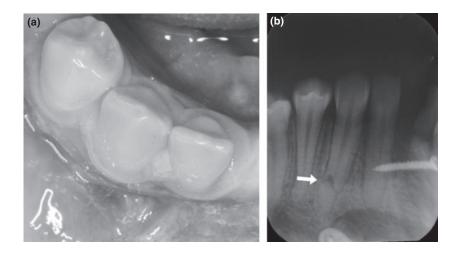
(a) Intraoral picture showing no evidence of fistulae or tissue change. (b) Periapical radiograph of the patient showing root fracture, with а radiolucent area (arrow), as possible root resorption. Note the well-defined smooth radiopaque outline immediately below the apex of 43 located at the mid line of the inferior periphery of the image field. This is a projection of the anterior extent of the surgical plate used for fracture reduction. The radiolucency extending supero-posteriorly to this area is a representation of a bony defect associated with the trauma.
